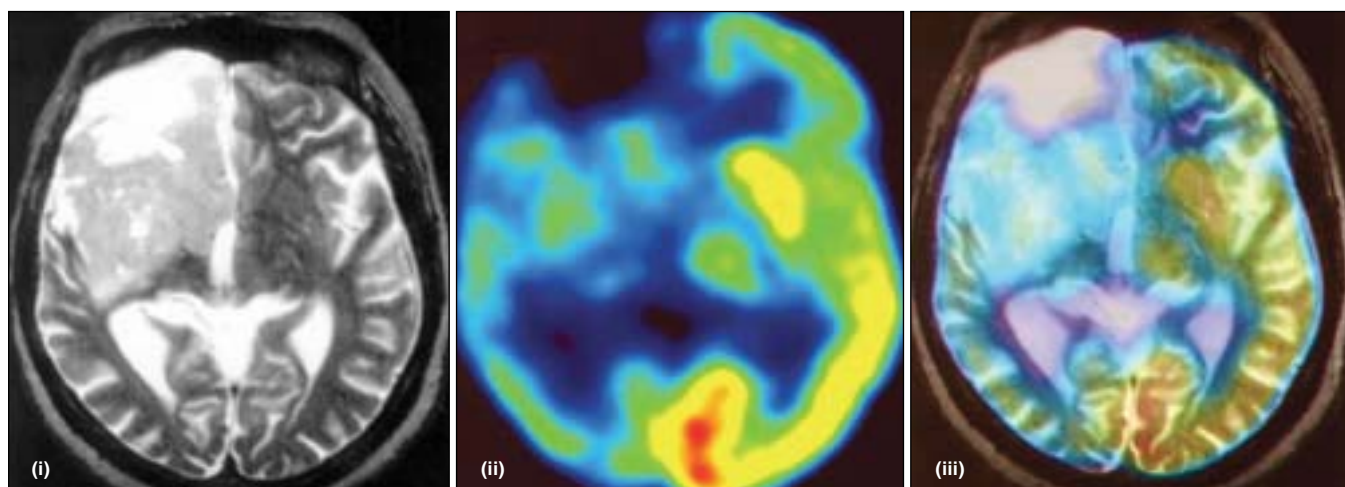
Neuroradiological features in 2003. The corresponding axial slice of MRT (i), ^{18}F FDG-PET (ii) and the merged co-registered scans (iii) made after 16 years of medical history. The tracer uptake of infiltrating right hemispheric tumor is elevated but does not approach the extent that was detected in 1996
